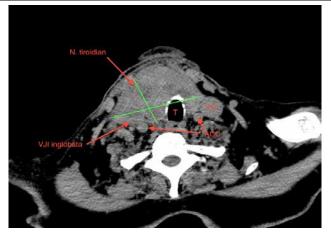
CT scan: Thyroid Gland Tumor with Internal Jugular Vein Invasion.
